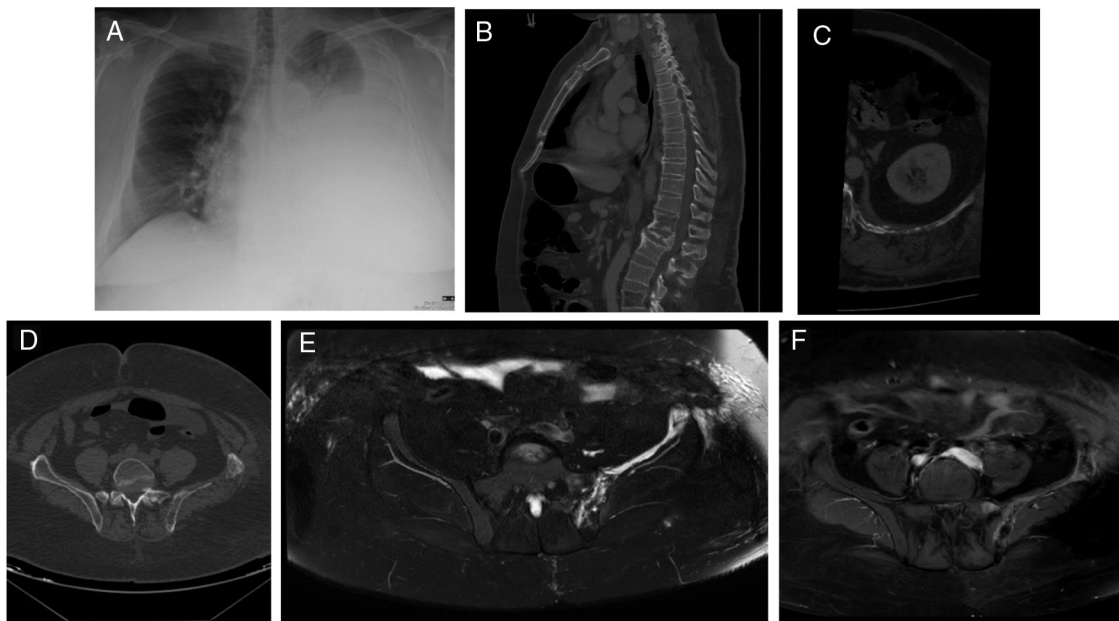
(A) Chest X-ray PA showed a radiodensity practically diffuse of the left hemitorax in relation to severe pleural effusion. (B) The sagittal reformatted CT image demonstrated a diffuse fat infiltration with loss of the trabecular bone pattern in the vertebral bodies T12 and L4 and an infiltration of the deep subcutaneous cellular tissue in the posterior abdominal wall. (C) The axial reformatted CT image showed multiple fatty lytic bone lesions with cortical disruptions in the 12th left rib. (D) Axial CT image demonstrated incomplete osteolysis of the left iliac bone with multiple fatty lytic bone lesions with cortical disruptions and without an increase of soft tissues. (E) Axial TSE-T2 weighted fat-suppressed image showed a diffuse hyperintensity of the left iliac bone, where linear structures are recognized that correspond to the dilatation of the lymphatic vessels. (F) This lesion presented an intense diffuse enhancement after administration of IV contrast on an axial TSE-T1 weighted fat-suppressed image.
